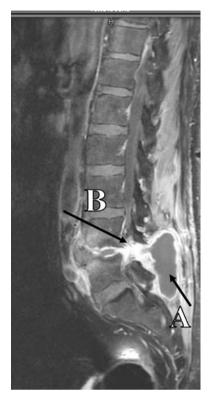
Sagittal magnetic resonance imaging (MRI) scan of the lumbosacral spine shows L4–L5 posterior paravertebral abscess (A) with spinal cord compression (*B*).
